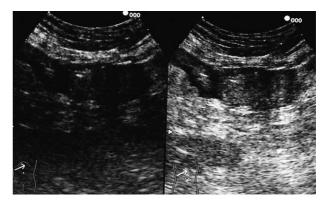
Left side: absence of contrast enhancement after 2'48" of Sonovue administration (late phase); right side: base-line ultrasonography
